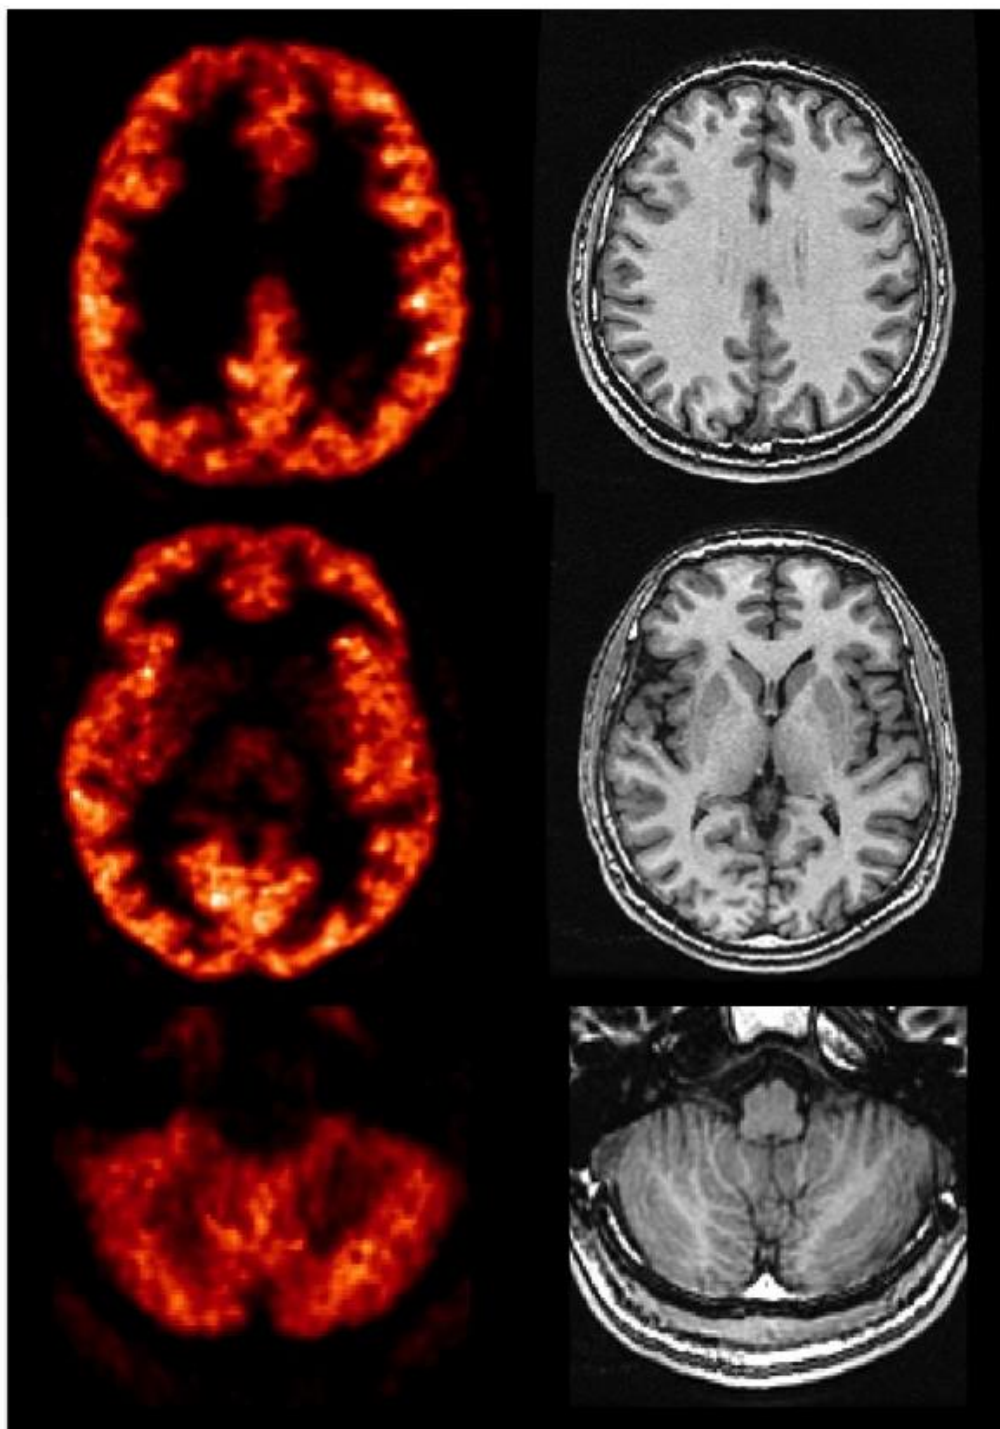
Parametric images of the $[^{11}\text{C}]\text{FMZ}$ Bmax from a single experiment on a High Resolution Research Tomograph (HRRT, left) with corresponding MRI (right) at subtentorial level (top and middle) and infratentorial level (bottom).
